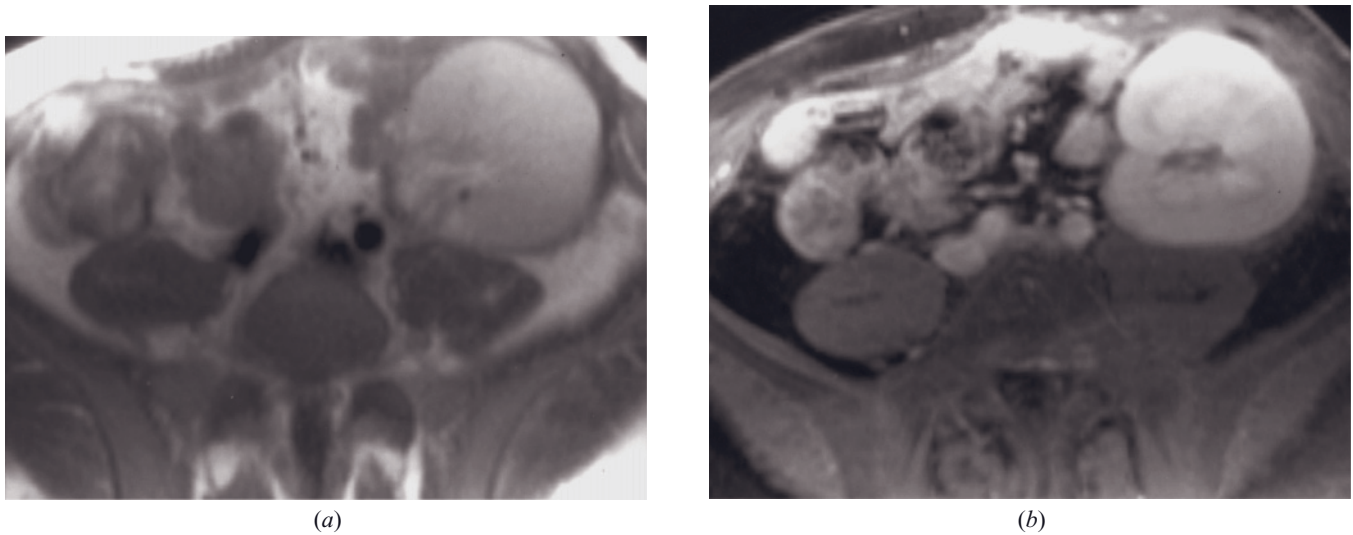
Transplanted kidney with rejection. T1-weighted precontrast (a) and 90-s fat-suppressed gadolinium-enhanced (b) SGE images. The renal transplant in the left pelvic fossa demonstrates decreased corticomedullary differentiation on the precontrast image (a) and appears globular or swollen. These findings are consistent with chronic rejection.
